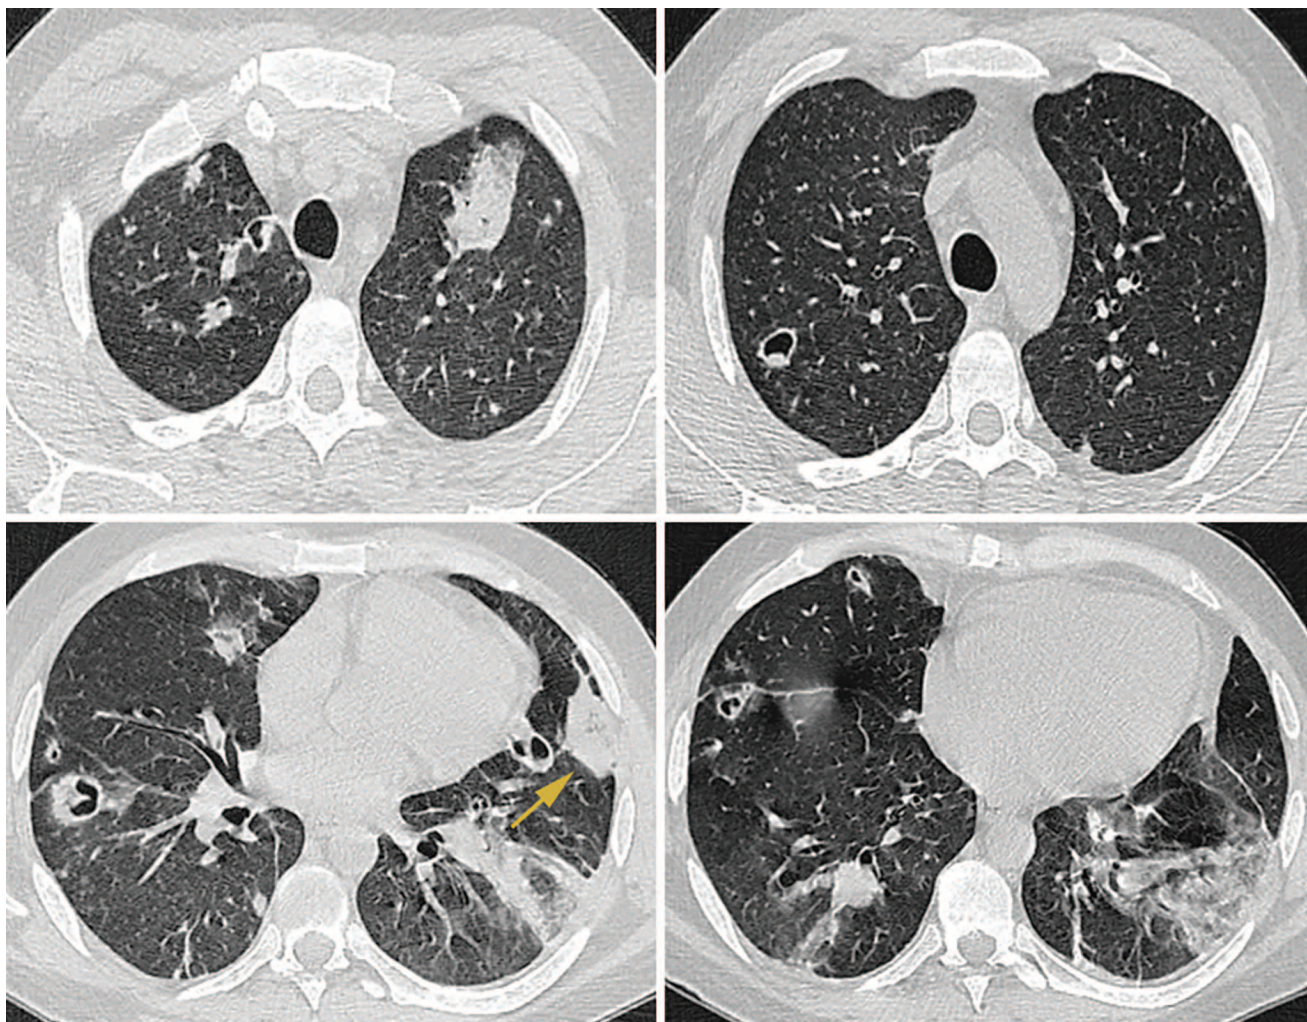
Transversal chest CT images of patient C. from 21.04.2020 z. In both lungs there are chaotic nodules and opacities of the lung tissue, multiple thin-walled cavities
